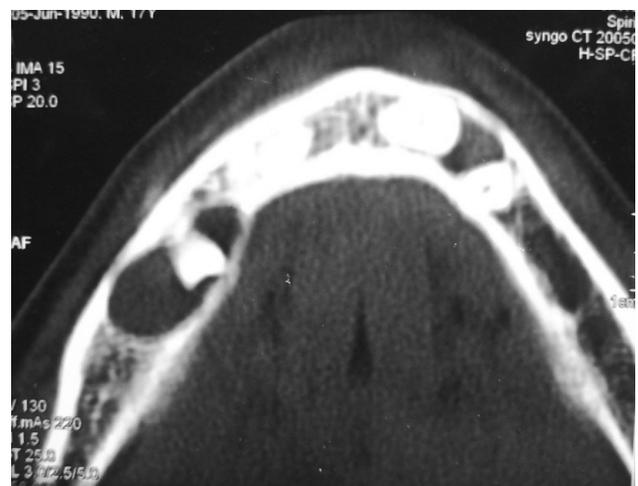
Axial CT image shows the buccal and lingual cortical plates of the mandible to be intact
